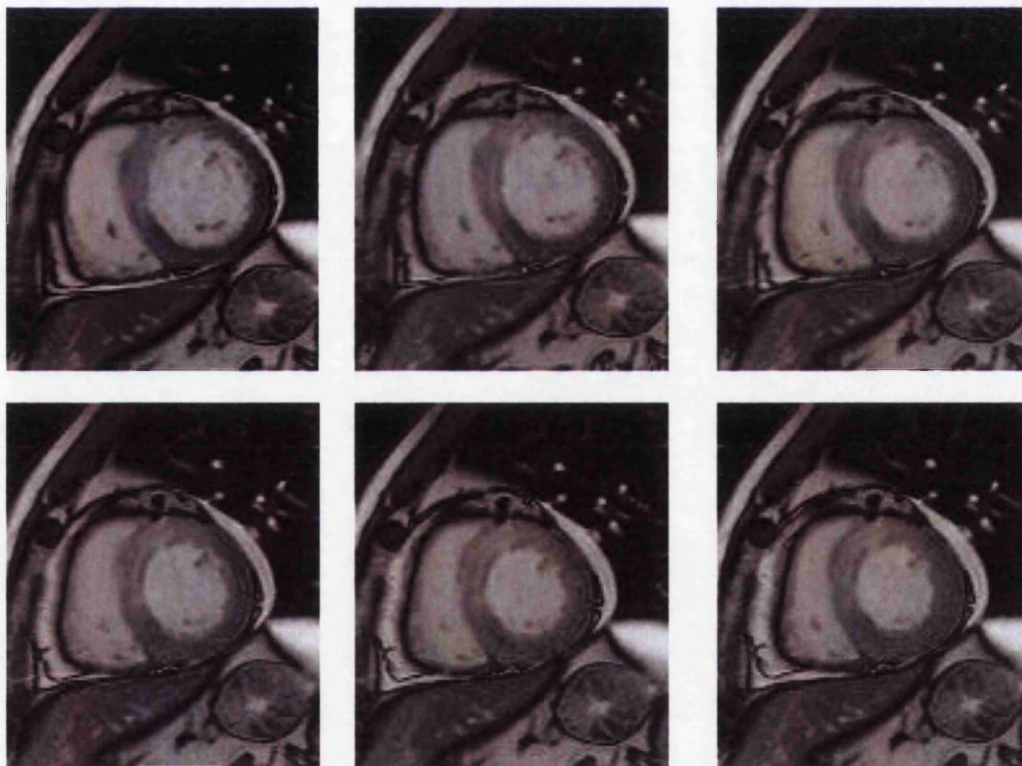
A sequence of post Gd-DTPA cine MR images from the short-axis view.
